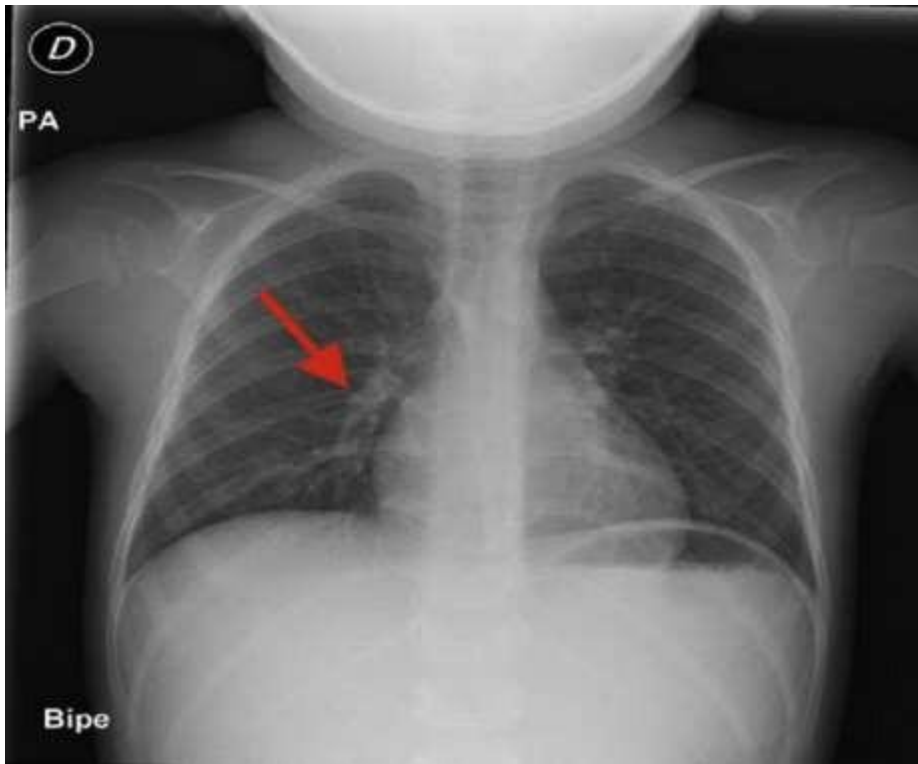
COVID-19 Pediatric patient: PA chest radiograph (Lopez de Munain et al., 2021).
